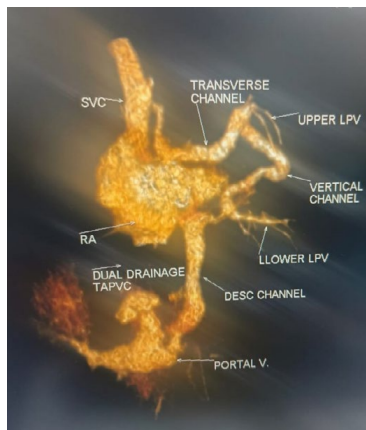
CT scan with 3D reconstruction is showing dual drainage TAPVC.
